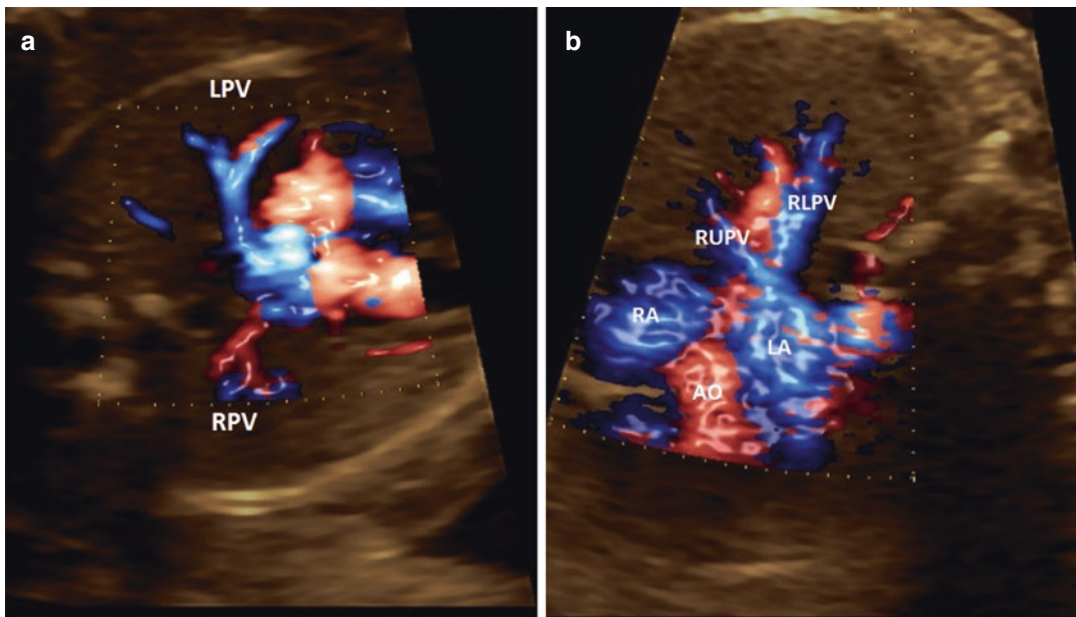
(a, b) Demonstration of enhanced flow (e-flow) color Doppler technique in normal pulmonary venous return using a Hitachi machine with a C6–1 MHz curvilinear probe. The right lower (RLPV), right upper
